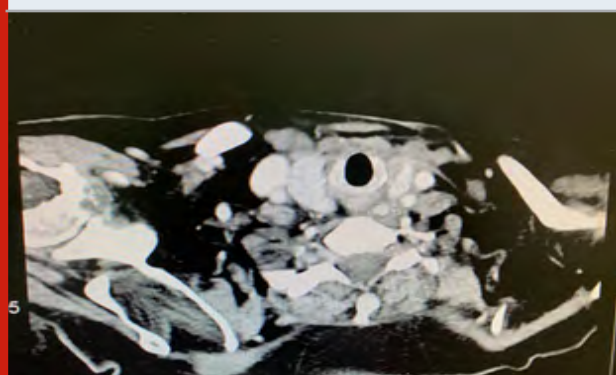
1b showed an axial neck computed tomography images demonstrate a large ill-defined mass infiltrating the thyroid gland.
